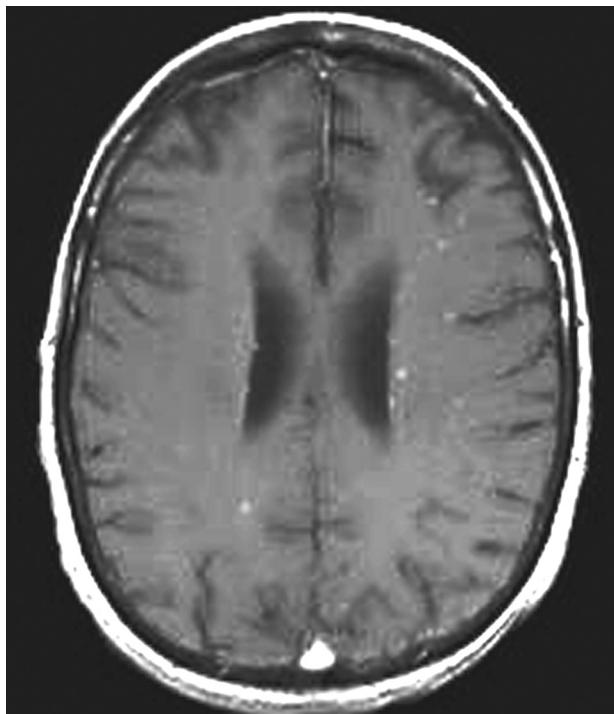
First MRI revealing multiple small contrast enhancing nodules representing intracerebral tuberculous granulomas. Lack of meningeal enhancement indicates that granulomas can occur without meningitis.
